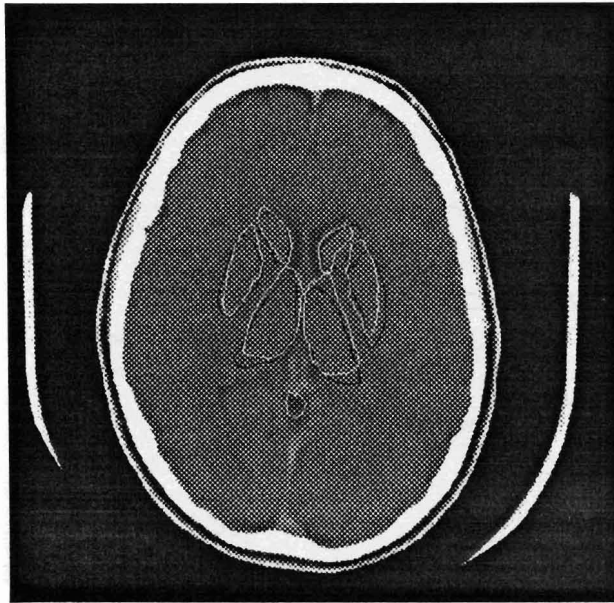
Comparing typical expert and typical computer. One of the experts generated outlines (shown in darker) and the computer generated outlines superimposed on the corresponding CT slice.
